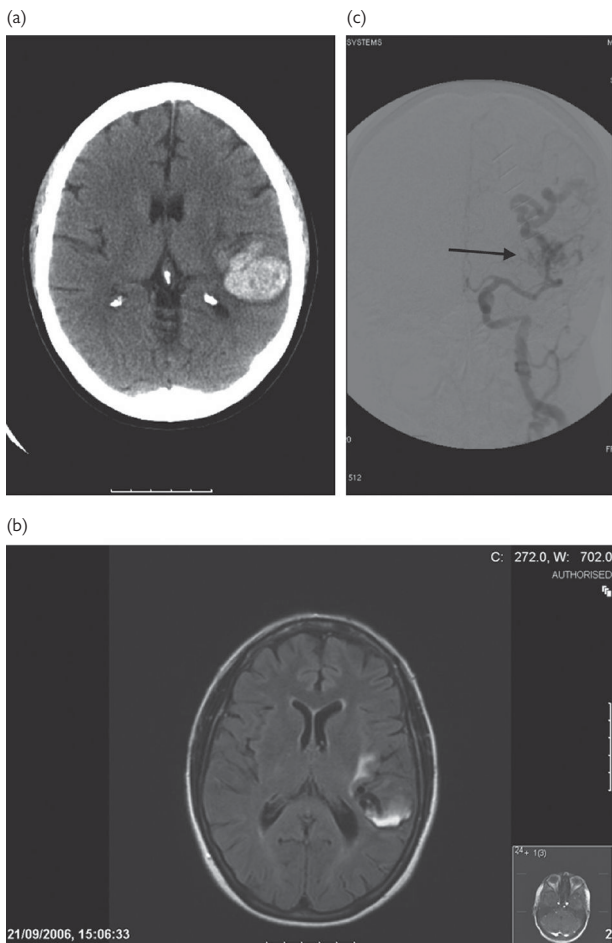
An AVM presenting with an ICH. This patient presented to the acute stroke unit. (a) The initial CT showed a left-sided cortical haemorrhage; (b) MR in the subacute stage showed a resolving haemorrhage as well as flow voids owing to dilated vessels; (c) an intra-arterial angiogram shows an AVM (arrowed). © Hugh Markus.
